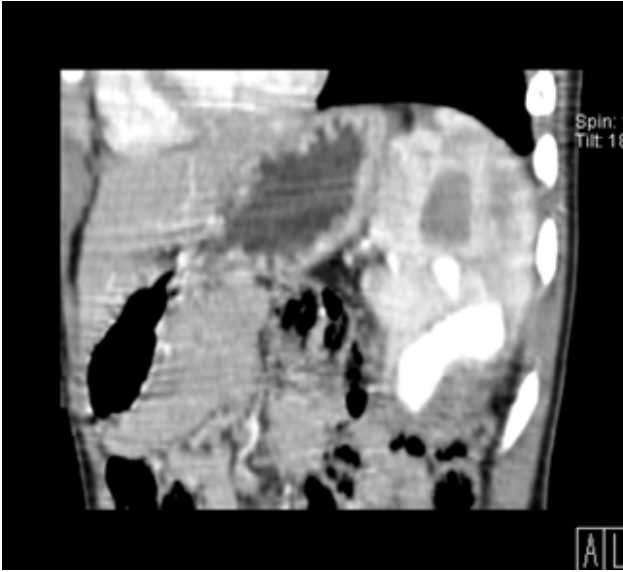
Contrast-enhanced sagittal CT, arterial phase. Contrast extravasation within a contained sac confirming a large pseudoaneurysm (arrow) in the inferior splenic pole.
